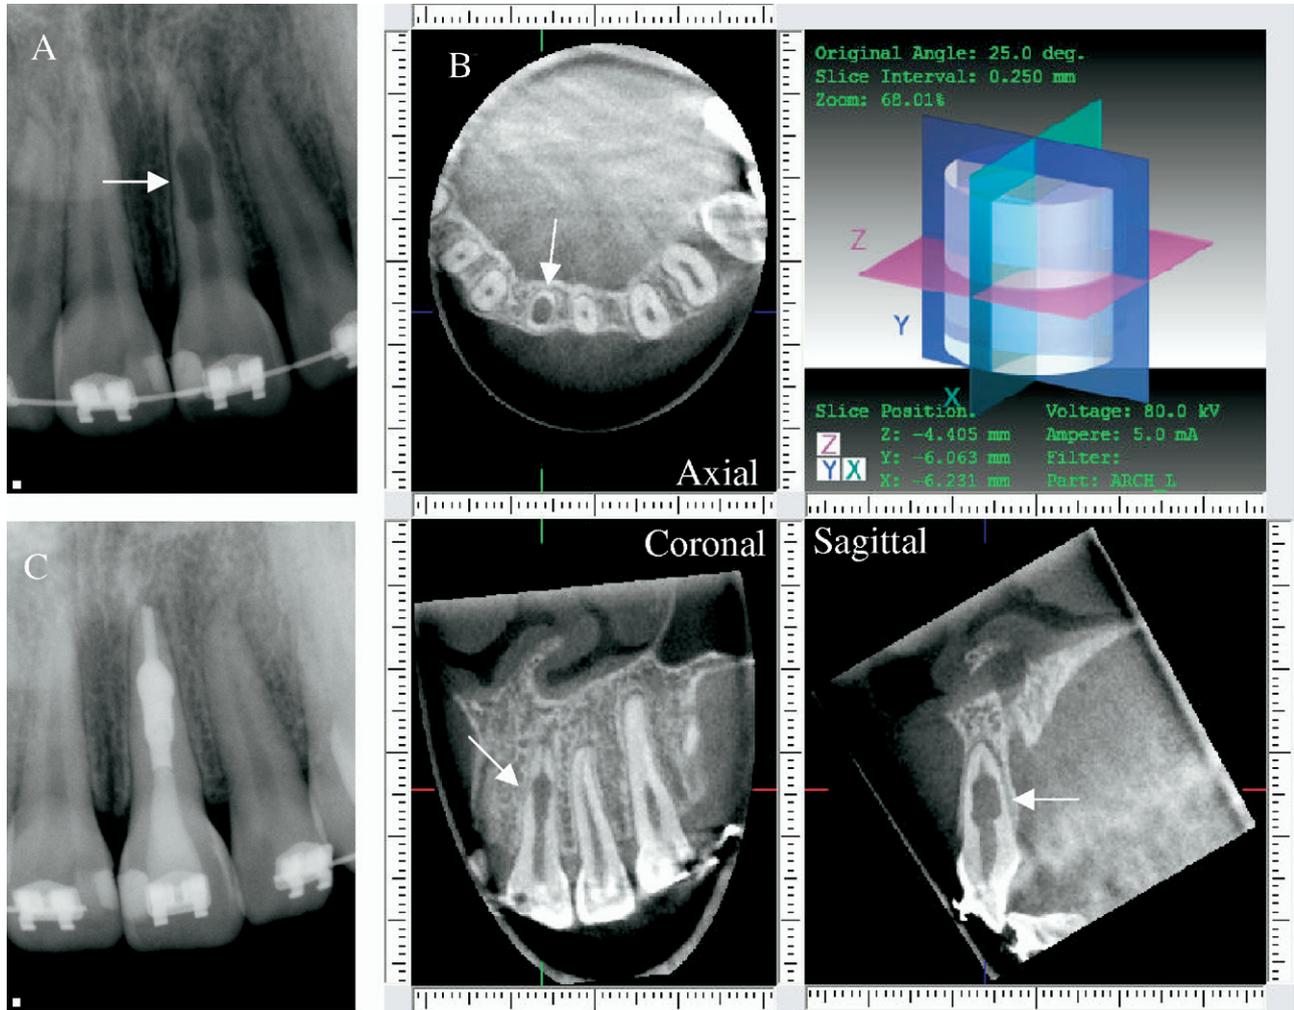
(A) Preoperative periapical radiograph depicts a distinct radiolucency associated with the root of #9 at the junction of the middle and apical thirds. (B) CBVT demonstrates the extent of the internal resorptive lesion in axial, sagittal, and coronal 2-D slices. (C) Postoperative periapical radiograph of the gutta-percha and mineral trioxide aggregate obturation of tooth #9.
